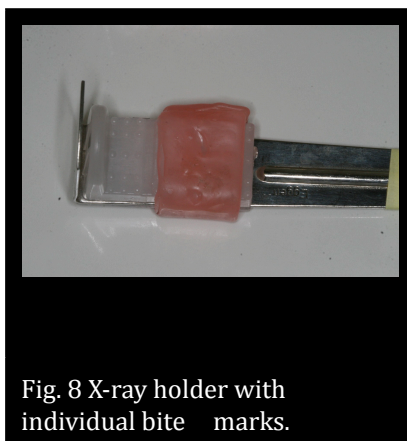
X-ray holder with individual bite marks.
